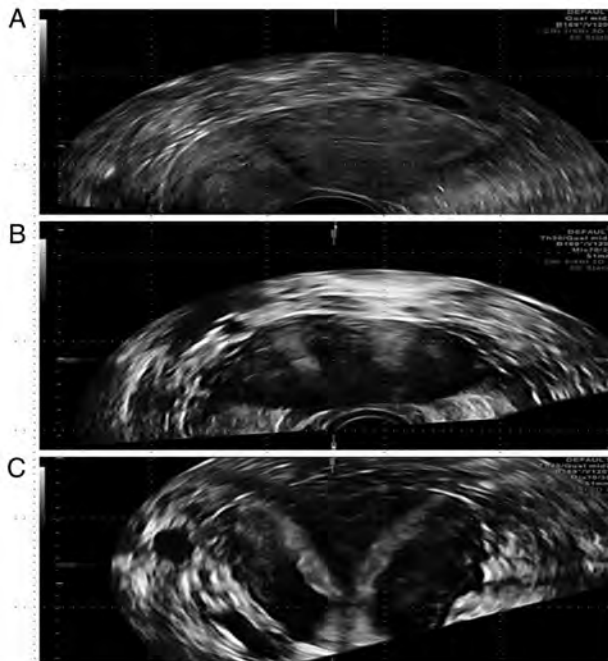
Septate uterus. (A) 2D ultrasound longitudinal plane of the uterus. (B) 2D transverse plane of the uterus. (C) 3D ultrasound, coronal plane of the uterus. 2D, two dimensional; 3D, three dimensional.
